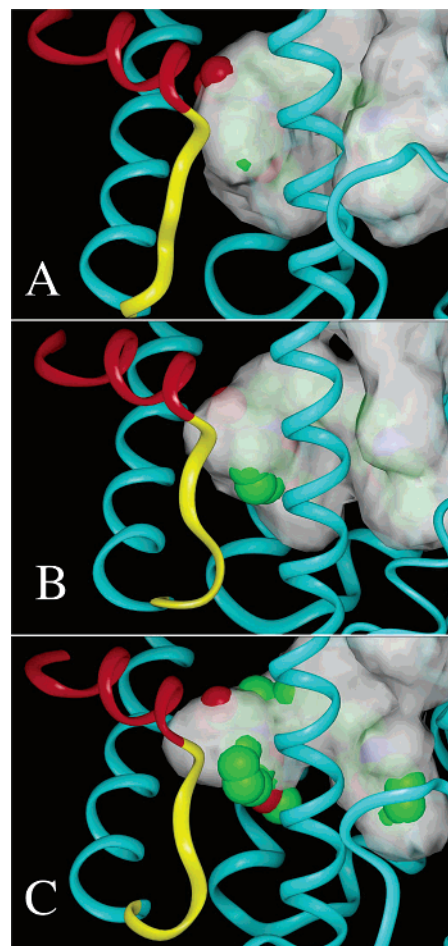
Models of GW7845 bound to each of the three PPAR subtypes in their active conformations. The ligand GW7845 was modeled into X-ray structures for the active conformations of (A) PPAR γ , (B) PPAR α , and (C) PPAR δ . In each case, the ligand is shown in a space-filling representation, with atoms colored green, blue, and red for carbon, nitrogen, and oxygen, respectively. The protein is depicted in a worm representation, colored red for the AF2 helix, yellow for the AF2 linker, and cyan elsewhere. The solvent-accessible ligand binding pocket is represented by a translucent white surface.
